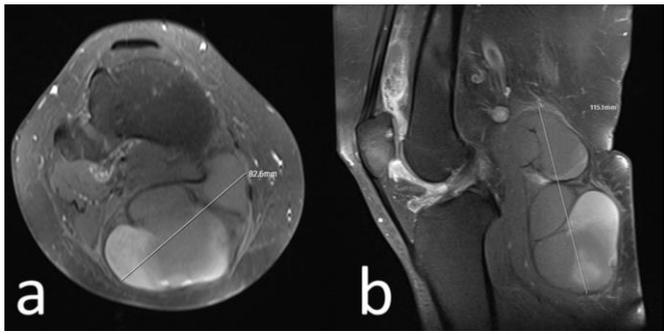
(a, b) Image of a Baker's cyst in the knee joint, taken using T1-weighted axial and sagittal MRI.
